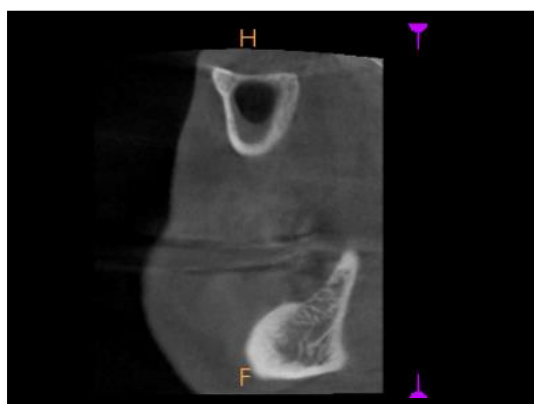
Sagittal view of CBCT showing bone invasion in the superior border of mandible.
